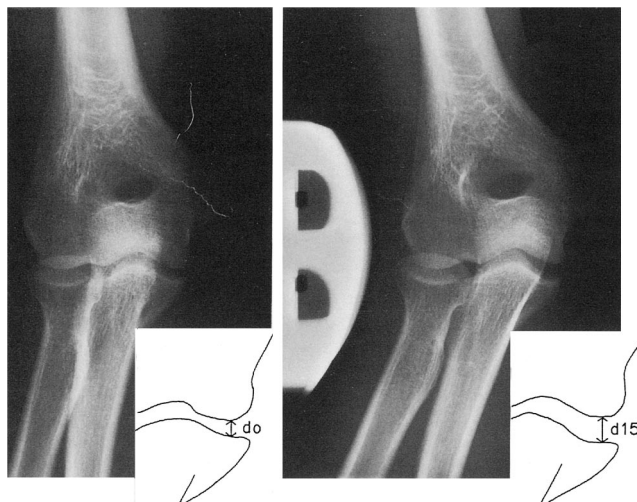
Anteroposterior radiograph of the left elbow with 0 force (d_0), and 15 daN force (d_{15}) applied to the elbow joint, showing increased medial joint spacing with application of stress. (Reprinted with permission from Rijke et al.⁹)
